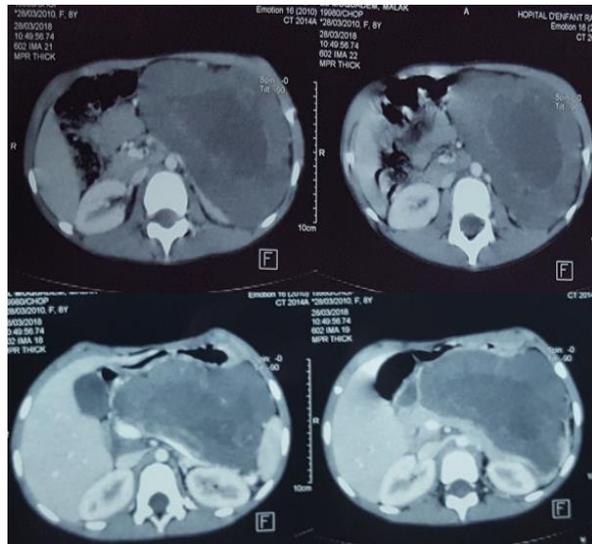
CT scan of the initial tumor before chemotherapy
